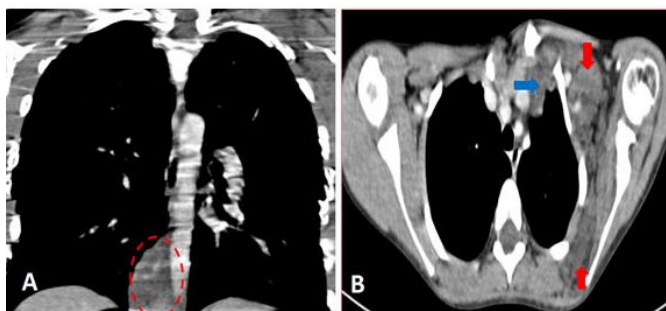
Chest CT scan in parenchymal window in coronal (A) and axial (B) sections shows a neurofibroma in the form of a right paravertebral mass (red circle), anterior mediastinal mass (blue arrow), and left subscapular extension (red arrows).
